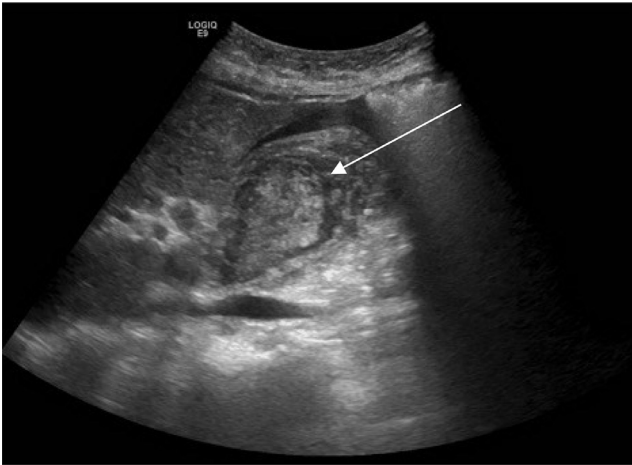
Right upper quadrant ultrasound, the white arrow shows heterogeneous echogenic content of the gallbladder, which may represent sludge or hemorrhage; there is also a thickened gallbladder wall.
